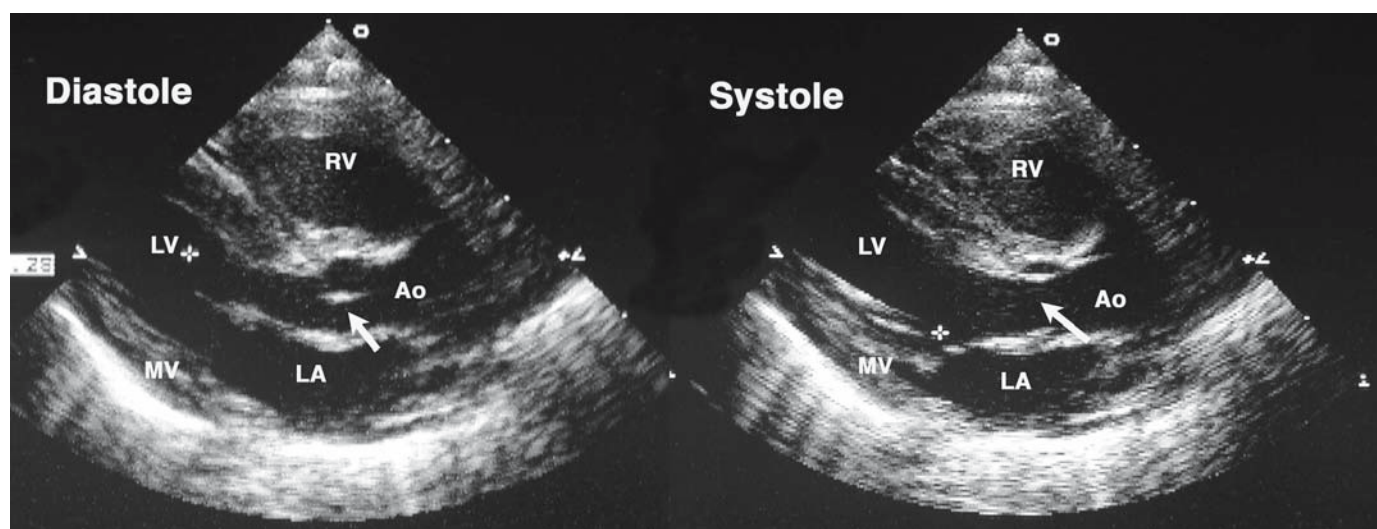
Transthoracic parasternal long-axis views in a newborn infant. These views demonstrate the long axis of the left side of the heart. Frame 1 is in diastole with an open mitral valve to accommodate left ventricular filling and a closed aortic valve (arrow). Frame 2 is in systole with an open aortic valve (arrow) and closed mitral valve (*). White dots on the sector border represent centimeter marks. Ao, aorta; LA, left atrium; LV, left ventricle; MV, = mitral valve; RV, right ventricle.
